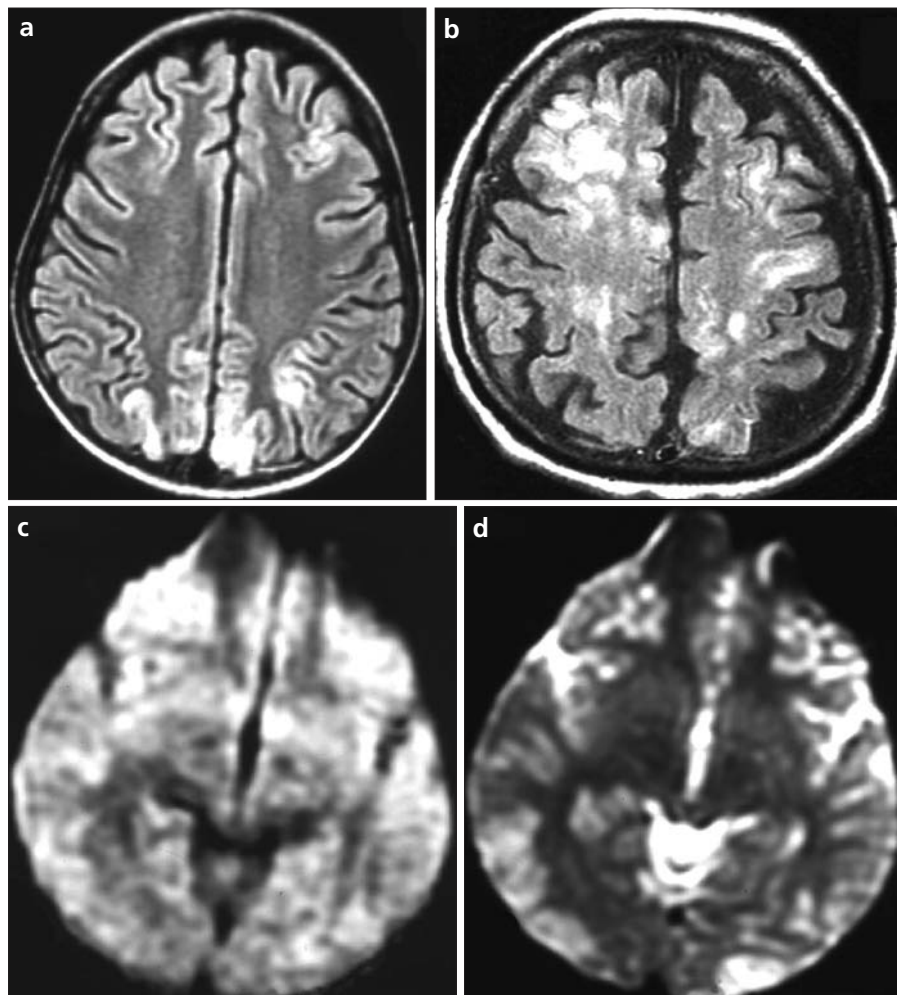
a-d. FLAIR transverse MR images (a, b) show cortical involvement in the parietal and frontal (a) and frontal and parietal (b) lobes of two different patients with posterior reversible encephalopathy syndrome who were diagnosed with acute lymphocytic leukemia and small cell lung cancer and treated with methotrexate and gemcitabine, respectively. Diffusion-weighted MR image (DWI; c) and apparent diffusion coefficient (ADC) map (d). There is no restricted diffusion noted on the DWI and the corresponding ADC map.
